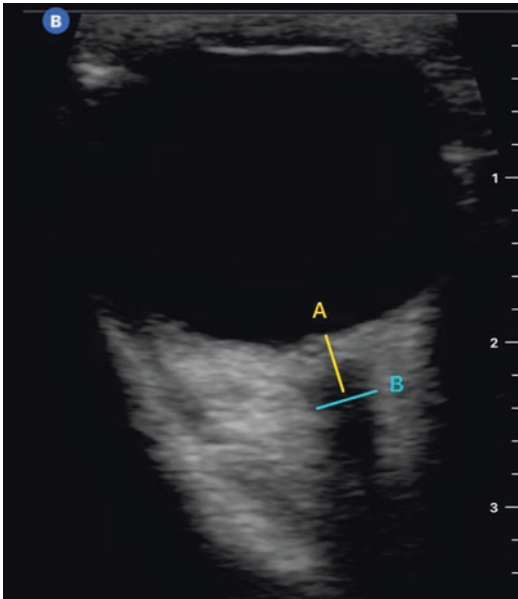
Identification and measurement of the optic nerve sheath diameter on ocular ultrasonography. (A) represents 3 mm posterior to the retina and (B) represents measurement of the optic nerve sheath diameter
